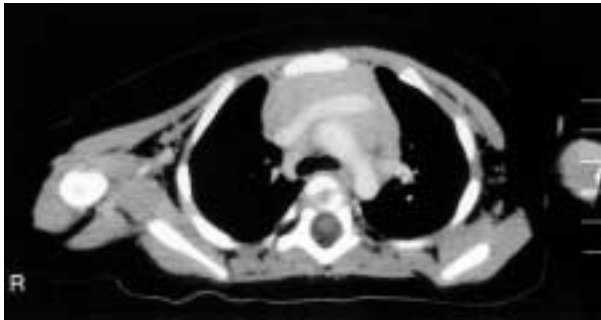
CT scan of the thorax. Computed tomography (CT) examination of the thorax shows a normal thymic shadow.
